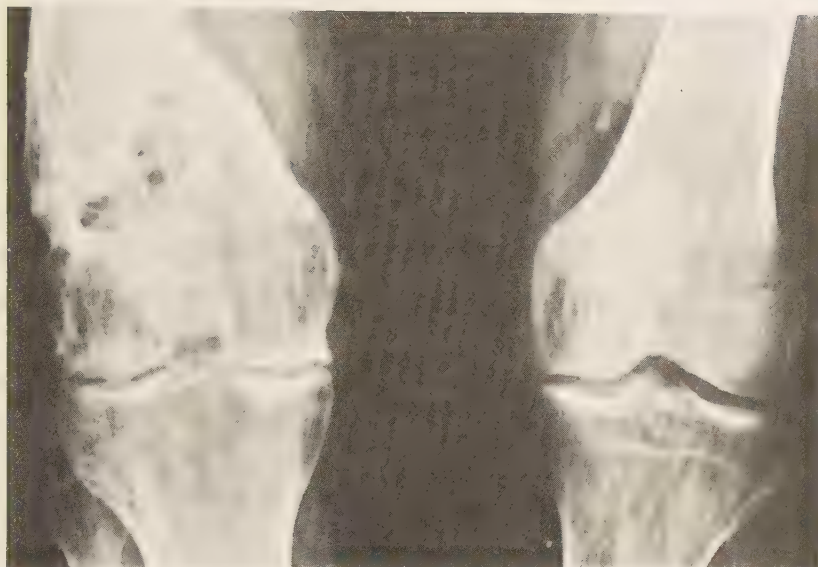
Standing radiographs of both knees stressed in valgus. Stage II medio-lateral gonarthrosis on the right side. Marked deformity of the supracondylar fracture. The HKA-angle was 192° (case B 32).
